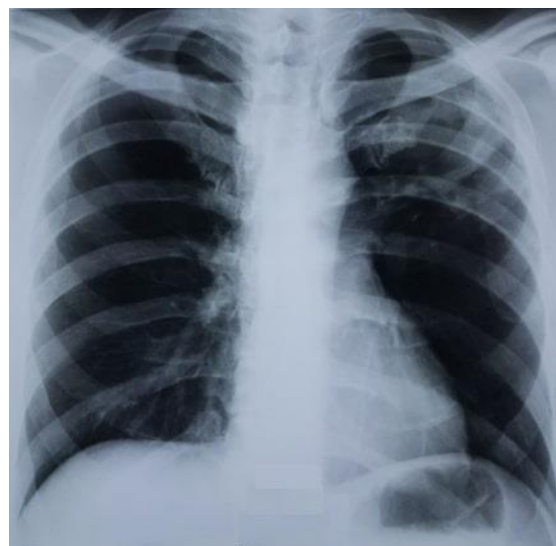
Chest X-ray at TB diagnosis – left upper lobe infiltrative nodular opacities and cavities
